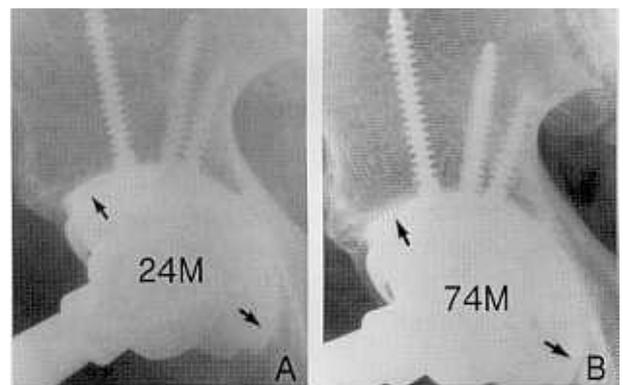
(A) Anteroposterior radiograph, 24 months postoperatively, shows a radiolucent line (arrow), 1 mm wide in zones I and III. (B) The radiolucent line (arrow) was unchanged at 74 months follow-up evaluation.
